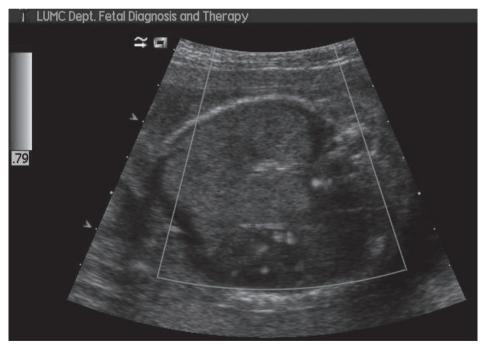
Color Doppler after laser therapy showing absence of flow to the lung lesion
